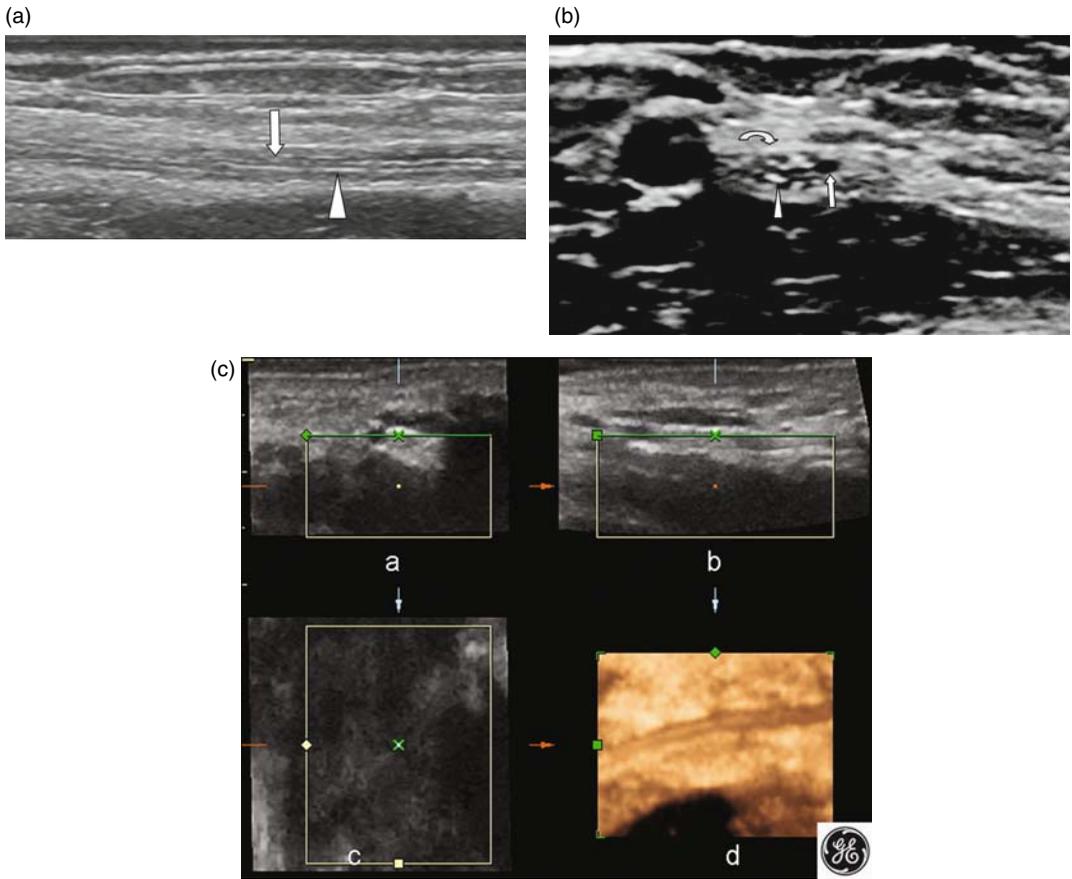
Peripheral nerve. (a) Longitudinal ultrasound of the medial nerve in the distal arm and (b) corresponding transverse image demonstrating the hypoechoic fasciculi (arrows) and the supporting hyperechoic interfascicular epineurium (arrowheads). The epineurium, seen on the axial image (curved arrow) as a thin hyperechoic rim of tissue around the periphery of the nerve, can be difficult to separate from perineural fat due to the same echotexture. (c) Ulnar nerve in Guyon's canal using 4-D transducer: (a) axial, (b) sagittal, (c) coronal, and (d) 3-D reconstruction.
